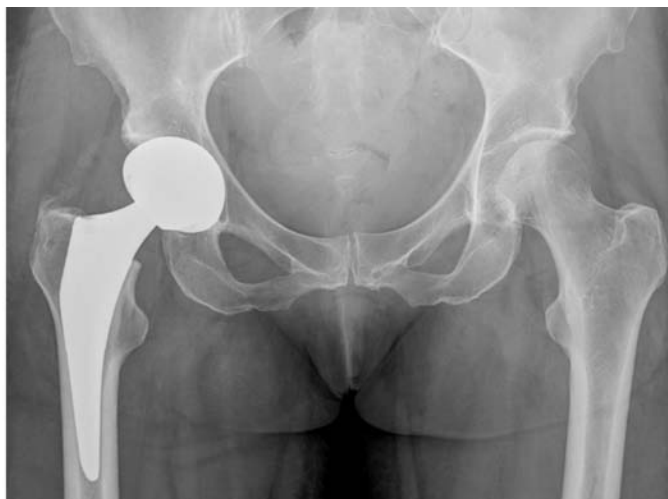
Left: Templated implants from OPST™ report; Right: postoperative radiograph.
